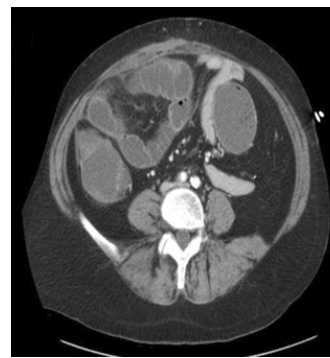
Axial CT scan demonstrating intact fascia patient after retrorectus repair prior to exploration for bowel obstruction. Some thickening of right and mid-abdominal wall noted from repair 14 months prior.
